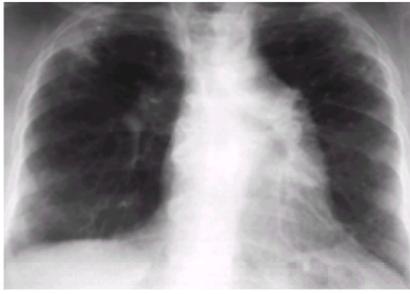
Chest radiograph of a patient with bird fancier's disease who was first seen with progressive dyspnea and weight loss. She had kept two or three parakeets in her home for the past 15 years and did not notice episodic fever or acute dyspnea. Her serum was positive for precipitins to parakeet serum, and she had severe restrictive disease and resting hypoxemia. Note the diffuse radiodensities, loss of volume of the upper lobes, and pulmonary hypertension.
